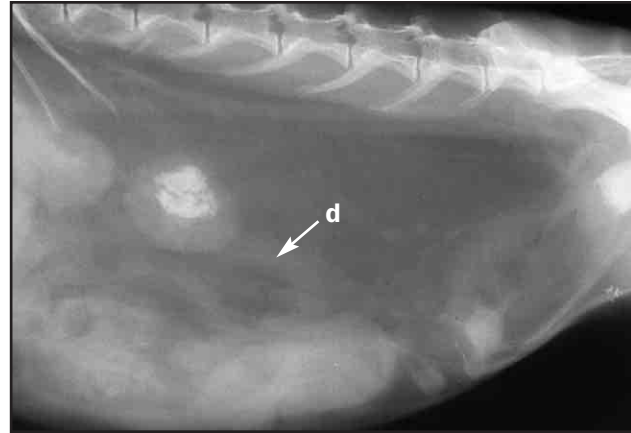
In this lateral radiograph taken 30 minutes after the injection of contrast, the left ureter (d) now appears to be dilated, and urine flow is delayed. In cases of unilateral nephrolithiasis, if one kidney appears to be functioning adequately, the surgical option of nephrectomy or nephrotomy to remove the urolith(s) from the affected renal pelvis may be considered.
